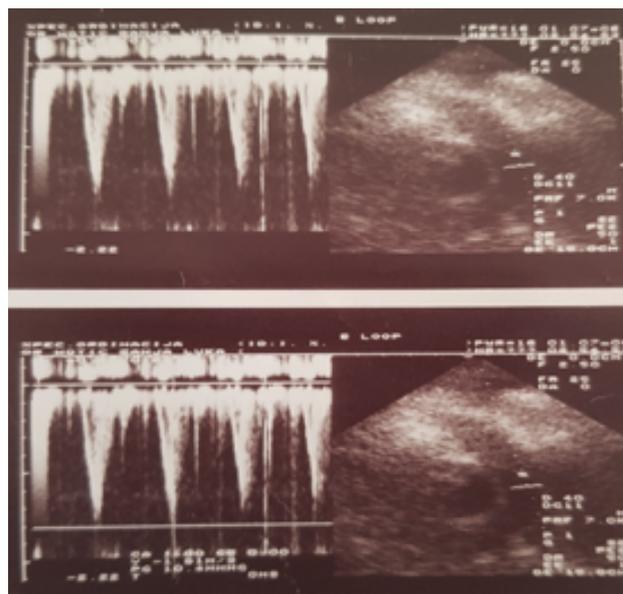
Ultrasound picture of primary cardiac lymphoma: The mass involving right ventricle of hearth. (Source: History of patient's illness)
